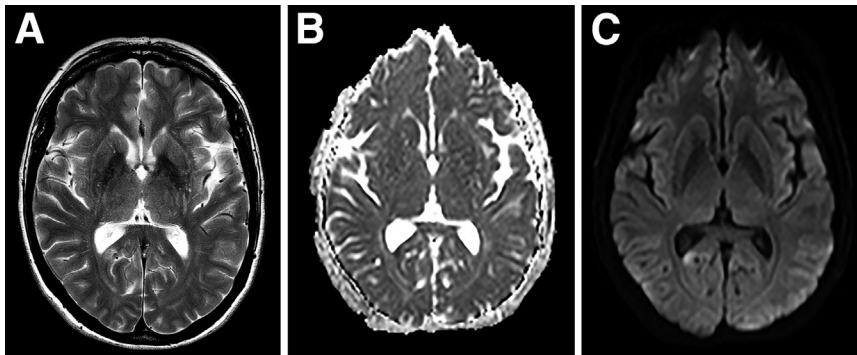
MRI brain scan. MRI (1.5 T) scan (transverse sections) of the brain showing a left posterior callosal (forceps major) lesion, hyperintense in the FLAIR (A) and diffusion-weighted (C) images and with decreased ADC values (B). Abbreviations: ADC, apparent diffusion coefficient; FLAIR, fluid-attenuated inversion recovery; MRI, magnetic resonance imaging.
